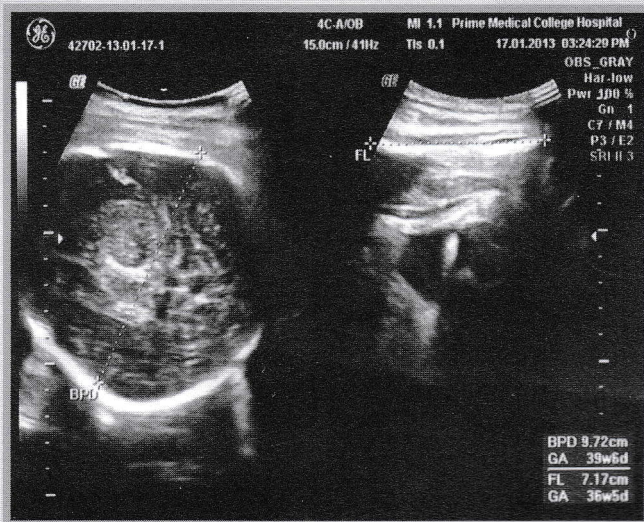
Foetus on Ultrasonography
